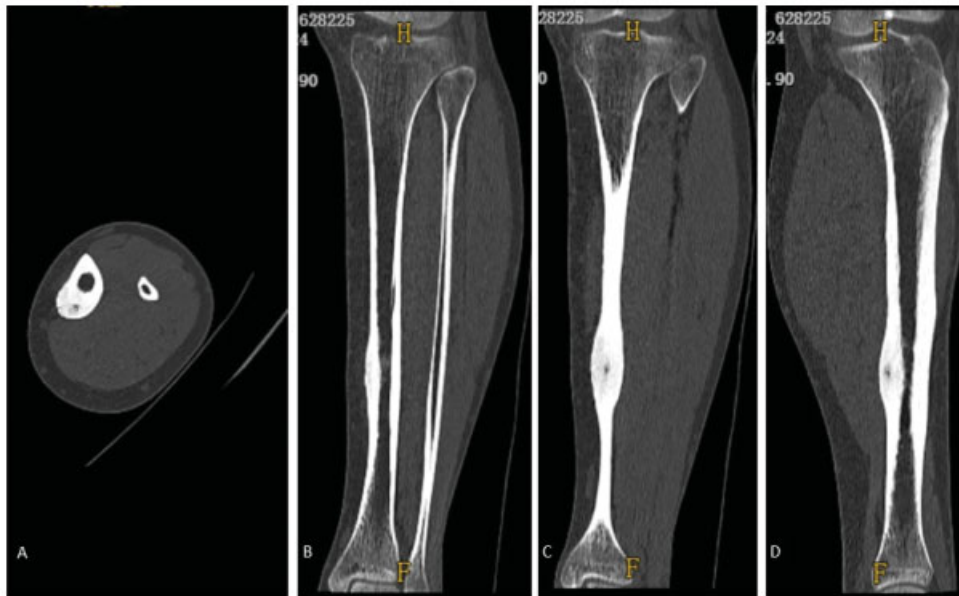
Computed tomography scans of the leg, A = axial section, B = coronal section, C = coronal section in a more posterior plane, D = sagittal section, showing lateral tibial cortical thickening and a lower density area in the juxtaposed posterolateral cortical region, consistent with an osteoid osteoma niche.
